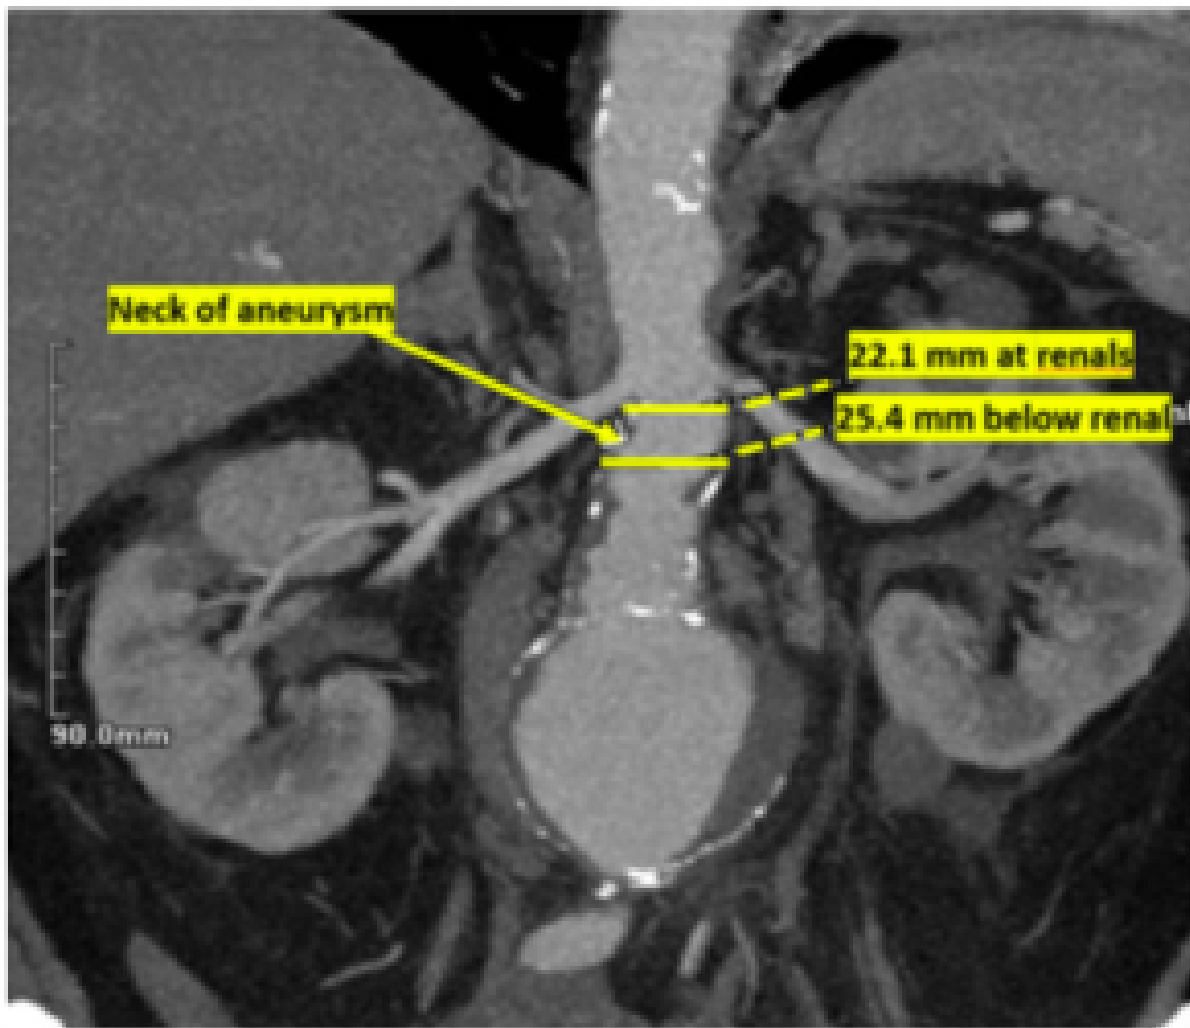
Coronal CT angiogram image shows 7.0 cm aneurysm. The diameter of the neck of aneurysm at the renal arteries were 22.1 mm and the renal arteries below were 25.4 mm.¹
